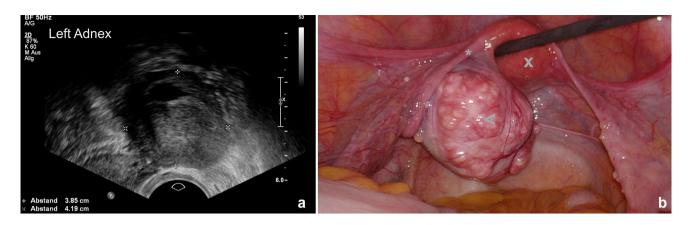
a IOTA-Sonogram of left adnex, b Laparoscopic image of the primary ovarian leiomyoma (<) with adjacent left fallopian tube (\*) and uterus (x)
